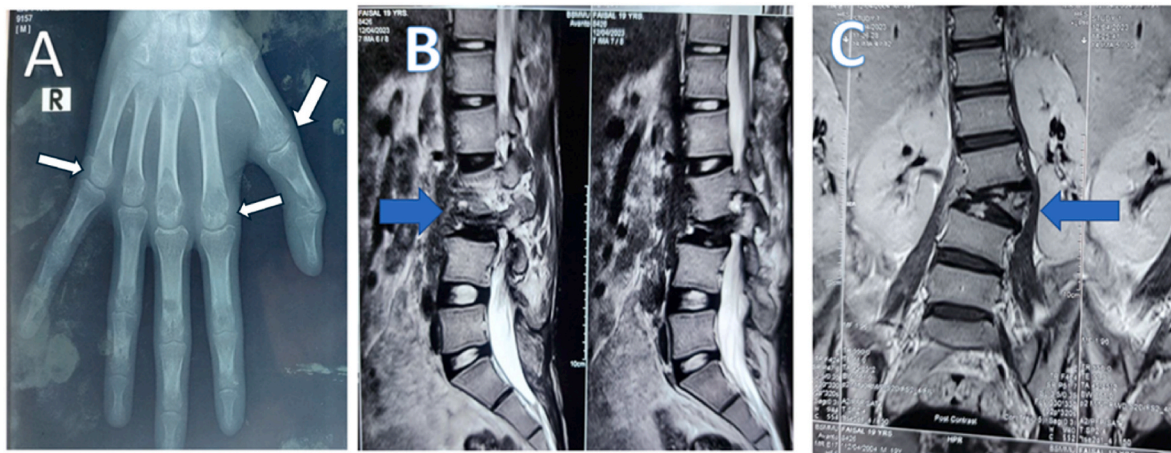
A) lytic lesions in X-ray hand (arrows), (B) and (C) pre- and para-vertebral soft tissue abscesses with disc involvement.
